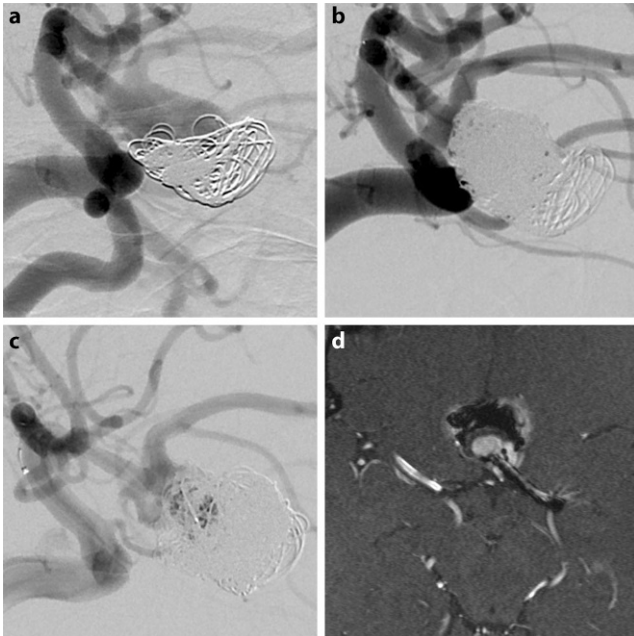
Patient 15 who had been previously treated by coiling of an aneurysm of the anterior communicating artery where a shows the aneurysm before the pCONus treatment, b shows the result of the pCONus assisted coiling, c and d show DSA and CE-TOF in MRI after 12 months depicting an obvious reperfusion of the aneurysm. The aneurysm has since been successfully recoiled
